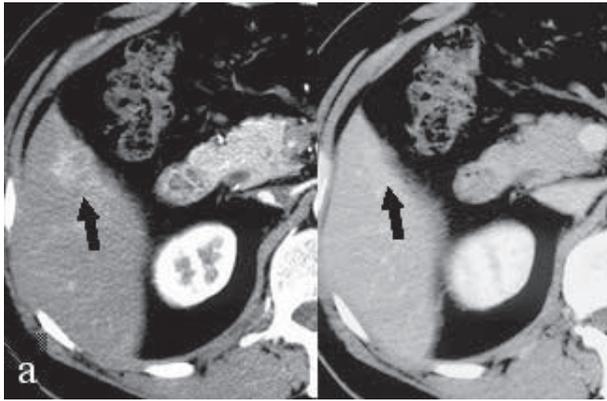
(a) An early-phase axial contrast-enhanced CT scan shows an enhancing nodule (*arrow*) in the right anterior inferior segment of the liver (*left image*). The nodule exhibits no contrast (*arrow*) with normal liver parenchyma in the delayed phase (*right image*). (b) An early-phase coronal contrast-enhanced CT scan shows the same nodule (*arrow*).
